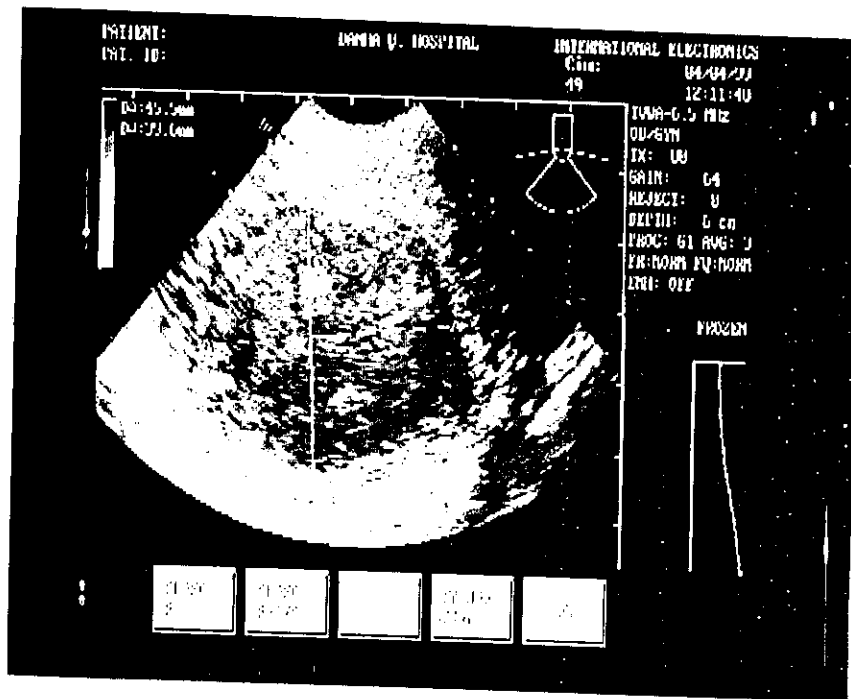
Shows sonographic picture of submucous leiomyoma.
